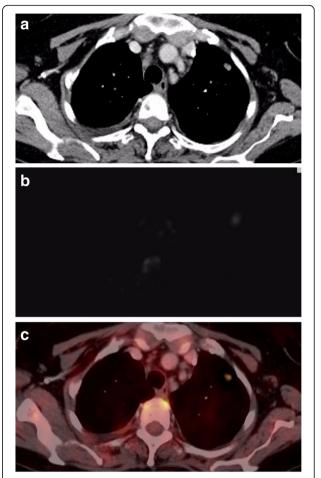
Lung metastatic nodule. a Axial contrast-enhanced CT, b FDG PET, and c fused PET/CT show left upper lobe small pulmonary nodule with marked FDG uptake (max. SUV  $\sim$  25)
